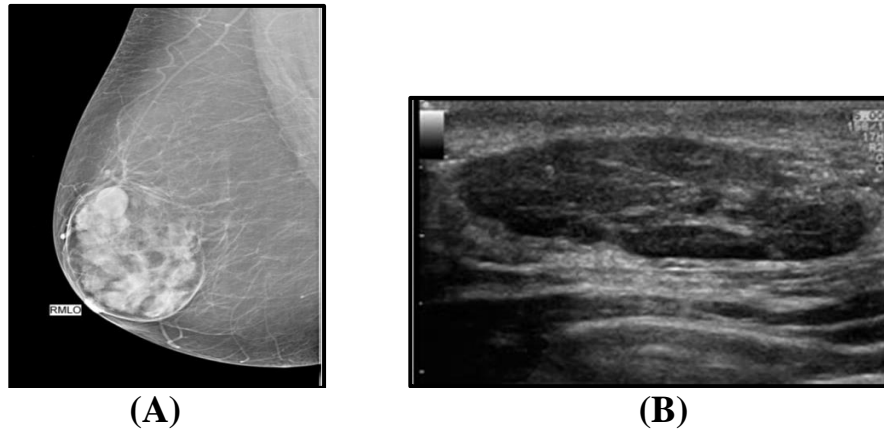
Breast Hamrtoma mammogram (A) and ultrasound (B) (Betty 2007)
